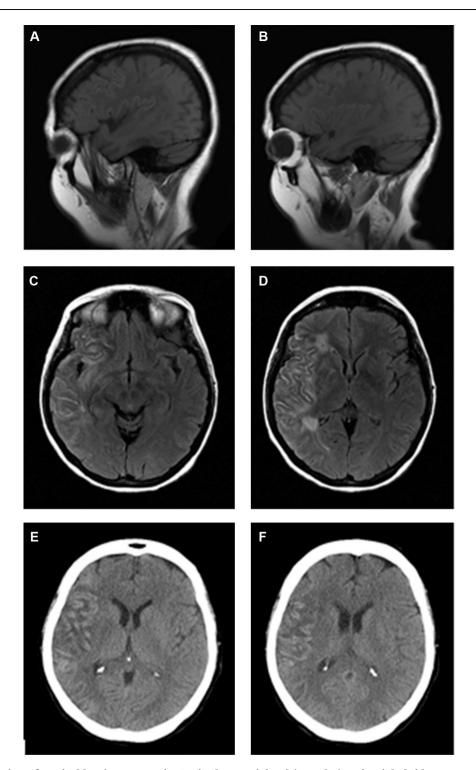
Neuroimaging of cortical laminar necrosis. Sagittal T1-weighted (A and B) and axial Fluid Attenuated Inversion Recovery (C and D) MRI sequences performed at 11 days from stroke onset showed curvilinear increased signal intensity following the gyral pattern of the cortex of the right fronto-insular and temporo-parietal ischemic regions. Brain CT scans (E and F) performed on day 22 displayed gyriform cortical hyperdensities in the ischemic area, prominently in fronto-insular and temporal lobes.
